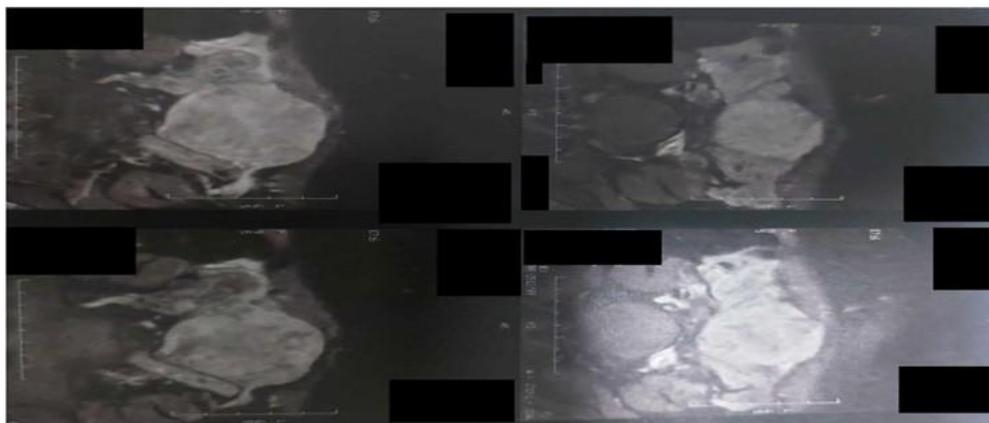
The MRI, that was also performed in this patient, led us to be more convinced that this is a case of endometriosis with mural localization.
